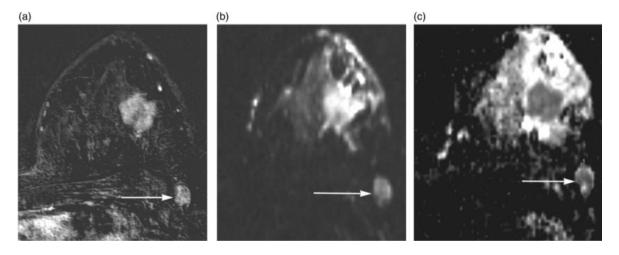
(i): 40-year-old woman with a surgically verified metastatic lymph node. (a) Axial early DCE 3D T1-weighted subtraction of the left axilla shows an enhancing lymph node (arrow). (b) Axial single shot-spin-echo planar DWI high signal intensity of the lymph node (arrow). (c) Axial ADC map (b values, 1000 mm²/s) shows the same lesion with restricted diffusion (arrow), the mean ADC of the lesion was 0.69 x 10⁻³ mm²/s.
